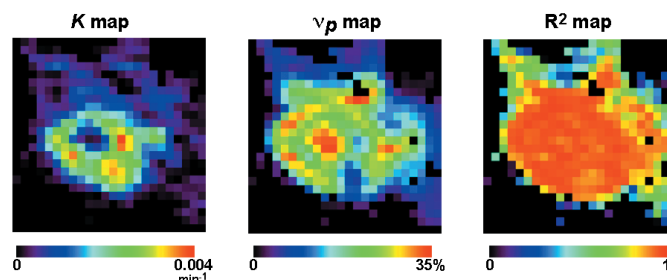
Parametric MR imaging of HDO perfusion in MCF7 human breast tumors. K - Perfusion rate, v_p - percentage of intravascular volume, R^2 - quality of fitting.
